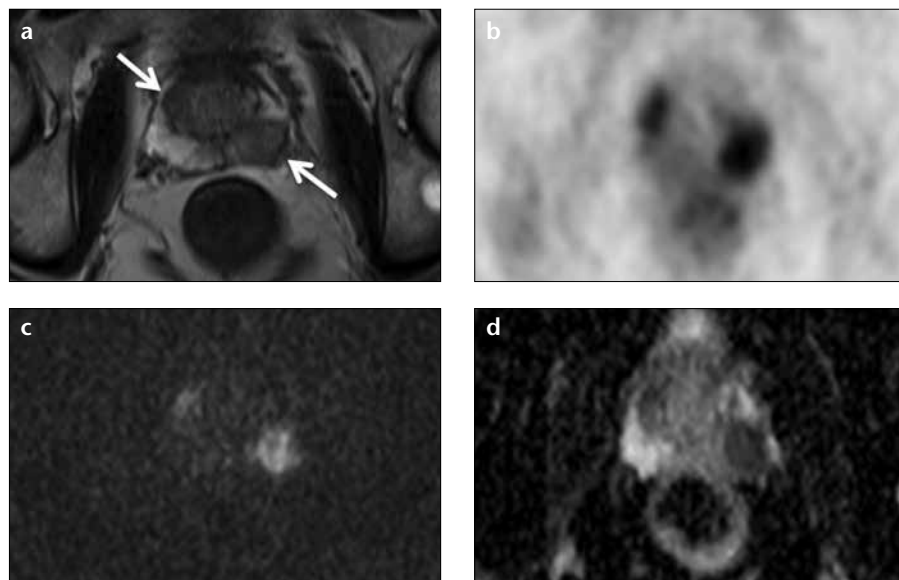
a–d. Combined morphological, functional, and metabolic imaging with simultaneous ^{18}F -choline PET/MRI of a biopsy-proven prostate cancer. T2-weighted image (a) showing a hypointense lesion in the left peripheral zone and right transitional zone (arrows). ^{18}F -choline PET image (b) derived from PET/MRI. Diffusion-weighted image (c) ($b=1500$) with high signal in the tumor lesions. ADC map (d) with corresponding low signal.
